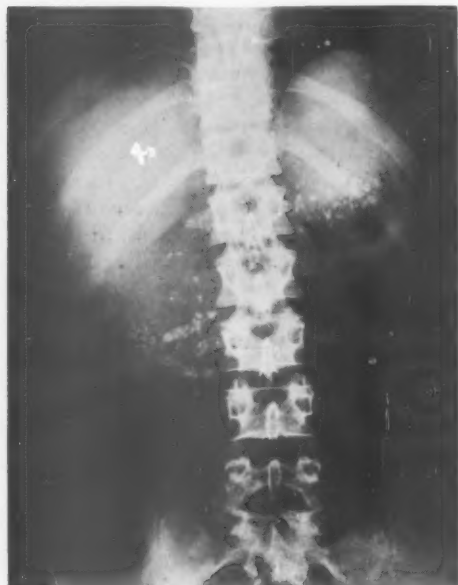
Flat plate of the upper abdomen in the case of V. J. (Case 5). Note the massive calcareous deposits, involving the head, body and tail of the pancreas. The head seems to be somewhat enlarged. Patient's pain originally was entirely right-sided, but after relief of this pain by right splanchnicectomy the pain shifted to the left. The X-ray indicates that the entire gland is involved in the calcareous process. The deposits disappeared from the head after prolonged pancreatic drainage.
